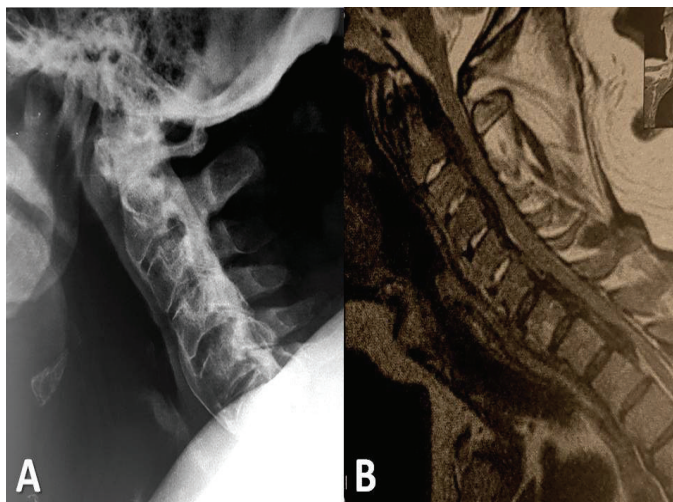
Pre-operative A) lateral cervical X-ray and B) T2-weighted sagittal cervical MRI demonstrating the diffuse type PLLO and secondary canal stenosis, with fusion of vertebral bodies and straitening of the cervical spine with fixed flexion position
